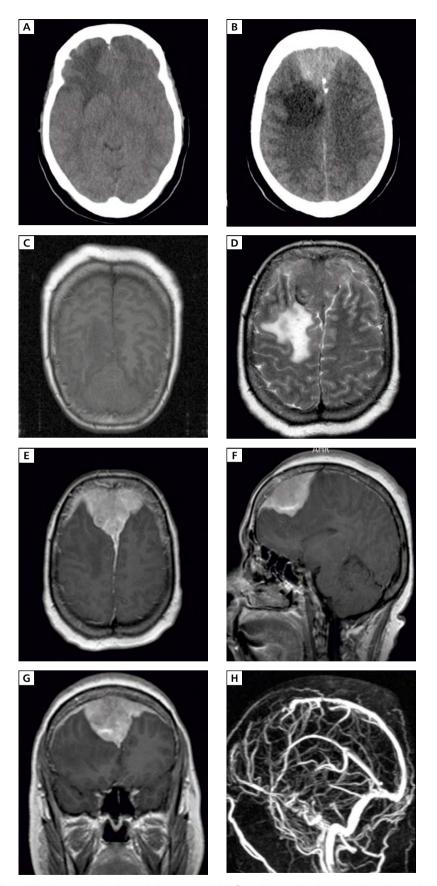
Preoperative axial brain CT scan (A, B) revealed an extra-axial bi-frontal parasagittal mass with peritumoral edema with iso-signal on T1 and T2 sequence (C, D) of MRI. Also, the lesion had bright enhancement (E–G) on MRI with gadolinium enhancement of the adjacent dura mater known as dural tail. On MRV, we can see the superior sagittal sinus completely occluded (H) in the location of the tumor
